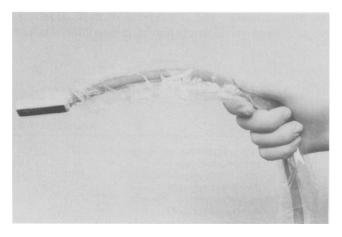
Sterilized ultrasound transducer. A disposable sterile latex cover is used to ensure sterility over the transducer and the flexible cable.
